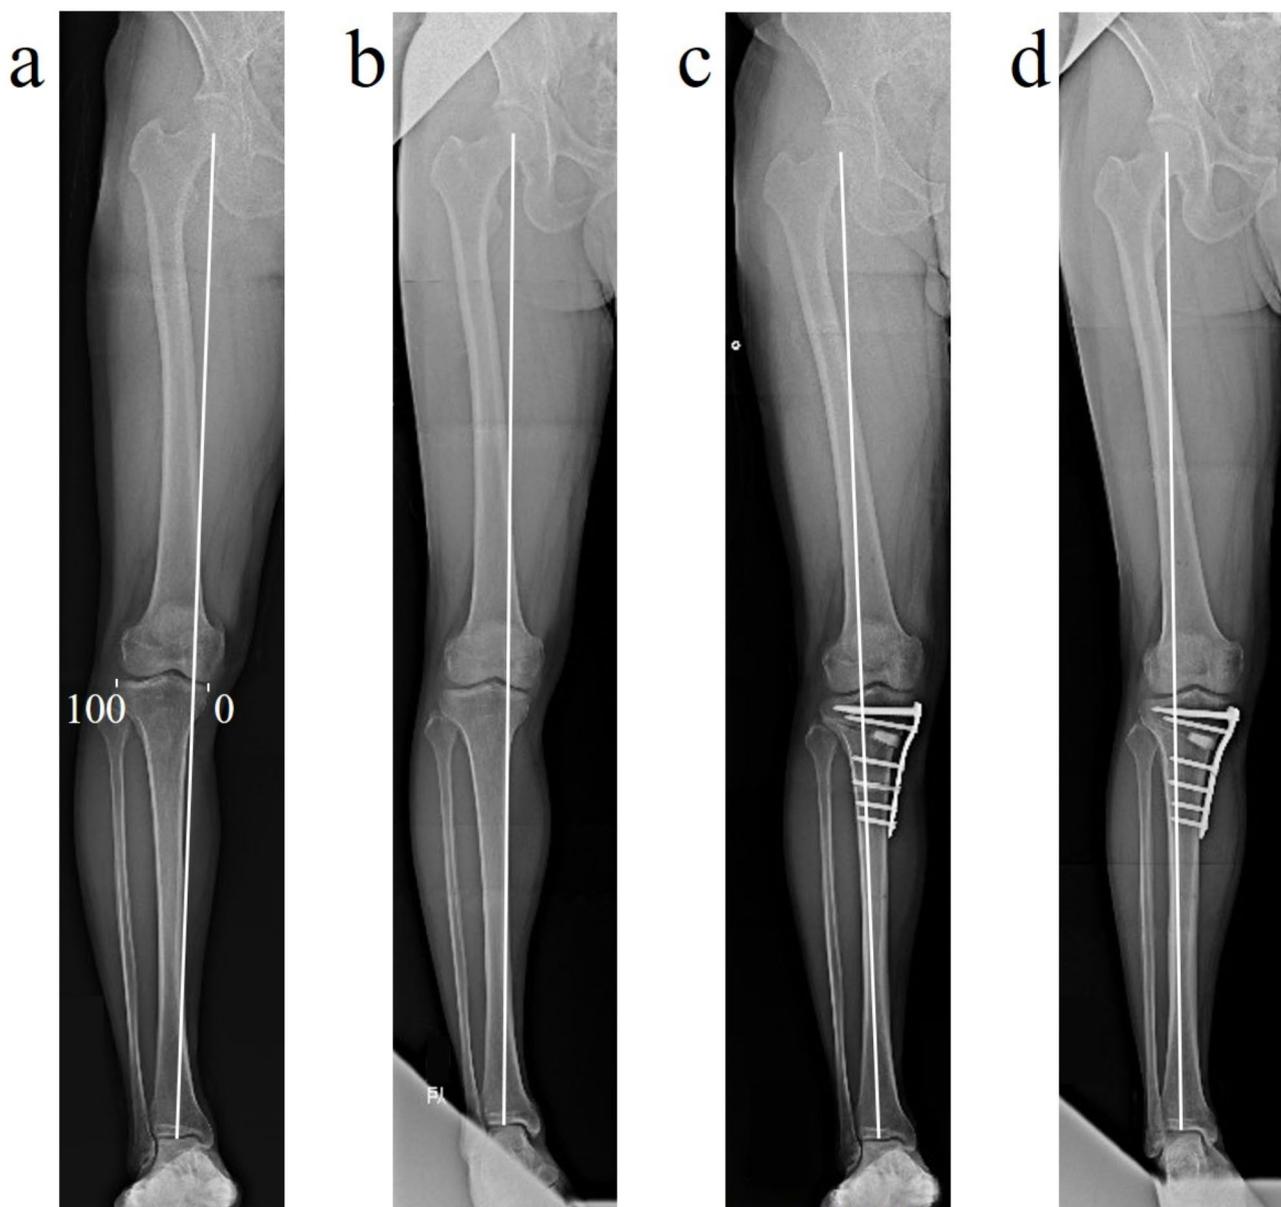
Radiographic analysis of mechanical axis (MA). a preoperative MA in the standing position. b preoperative MA in the supine position. c postoperative MA in the standing position. d postoperative MA in the supine position
